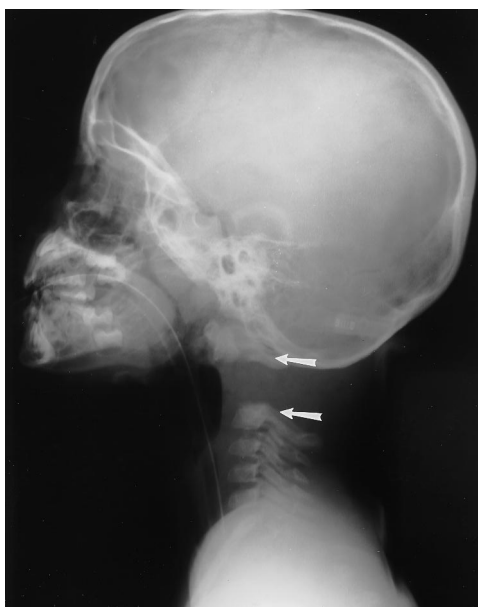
Fatally injured, unrestrained forward-facing child passenger. Postmortem radiograph shows fracture distraction injury through the C2 subdental synchondrosis (arrows).
